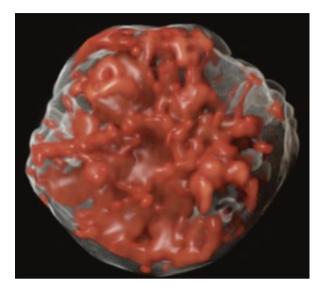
Power Doppler showing flow in the ovarian stroma
